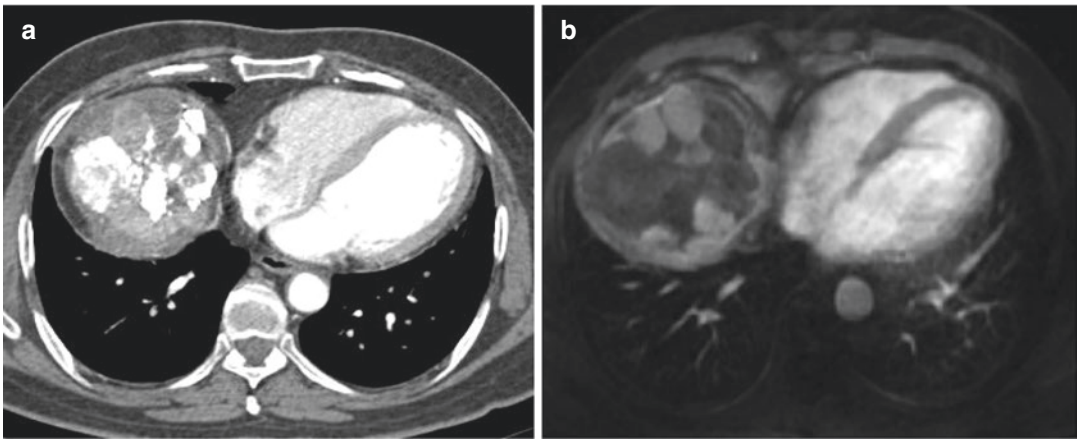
(a, b) Post cTACE arterial phase CT image and arterial phase MRI showing residual disease. The non-lipiodol uptake viable tumor is better appreciated on MRI scan
